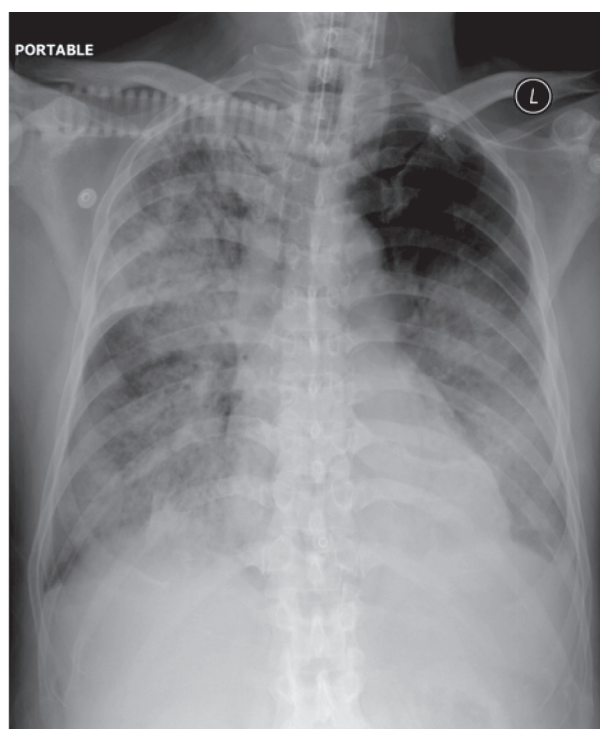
On Day 2, chest x-ray showed progressive pulmonary infiltration at both lungs.
